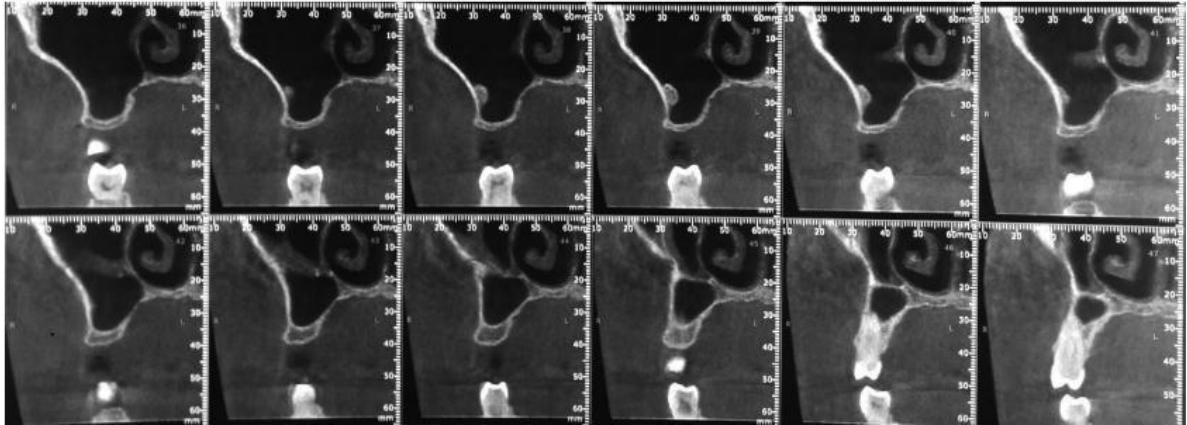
CBCT oblique coronal sections showing vertical defect and sinus osteoma (Mlouka et al., 2021c)
